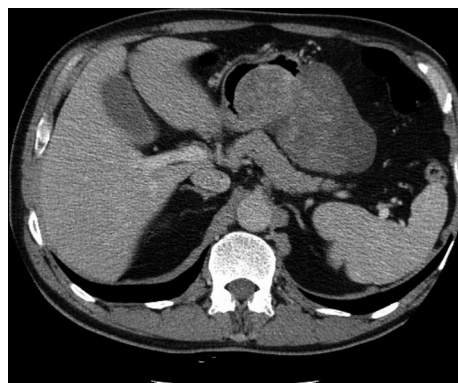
Computed tomography scan revealed a tumour-like mass projecting to the lumen of the stomach, adjacent to the greater curvature area.
